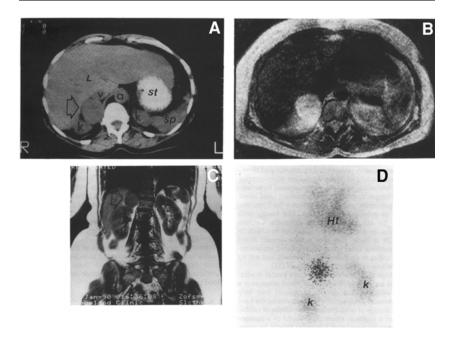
(A) Abdominal computed tomography scan at the level of the adrenal glands. a, aorta; k, kidney; L, liver; sp, spleen; st, stomach; v, vena cava. Arrow points to a solid suprarenal mass in the area of the right adrenal gland and measures about 6.0 cm in greatest diameter. (B) Magnetic resonance imaging (MRI) scan with T_2 -weighted partial saturation sequences demonstrates the high signal intensity typical of pheochromocytoma. (C) Coronal section of the MRI scan with T_1 -weighted saturation sequences demonstrating the mass (arrow) above the kidney and medial to the liver. (D) [¹³¹I]MIBG scan. Adrenal scintigraphic image at 48 hour after intravenously administered [¹³¹I]metai-odobenzylguanidine. Focal increased right suprarenal ¹³¹I activity consistent with a right adrenal pheochromocytoma. Ht, heart; k, kidney. (From ref. *17a*.)
